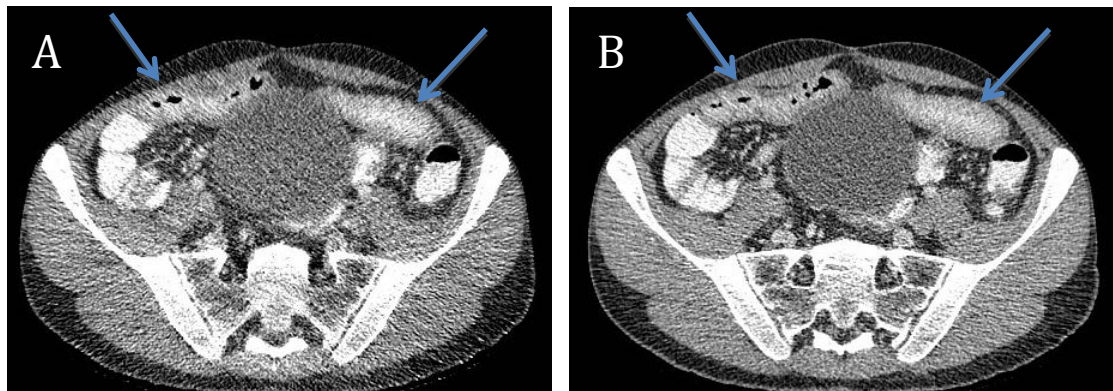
Modified (A) and conventional (B) dose axial CT reconstructions of the abdomen and pelvis of a 34 year old man with a BMI of 19.9kg/m² demonstrating small bowel thickening with adjacent mesenteric fat stranding and hypervascularity indicative of acute enteritis (blue arrows). The modified dose CT was acquired with an effective dose of 0.62mSv with the conventional at 2.6mSv.
